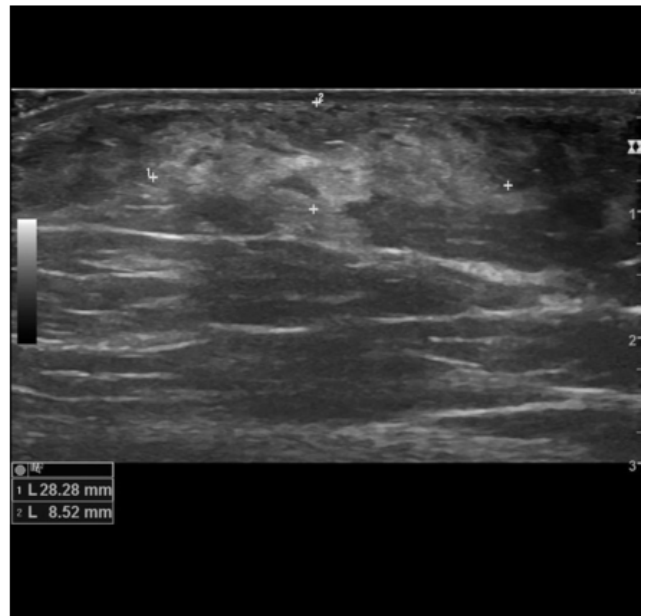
The ultrasound showed a heterogeneous hyperechoic area below the skin same as normal glandular tissue of breast not connected to pectoral breast in left axilla.
